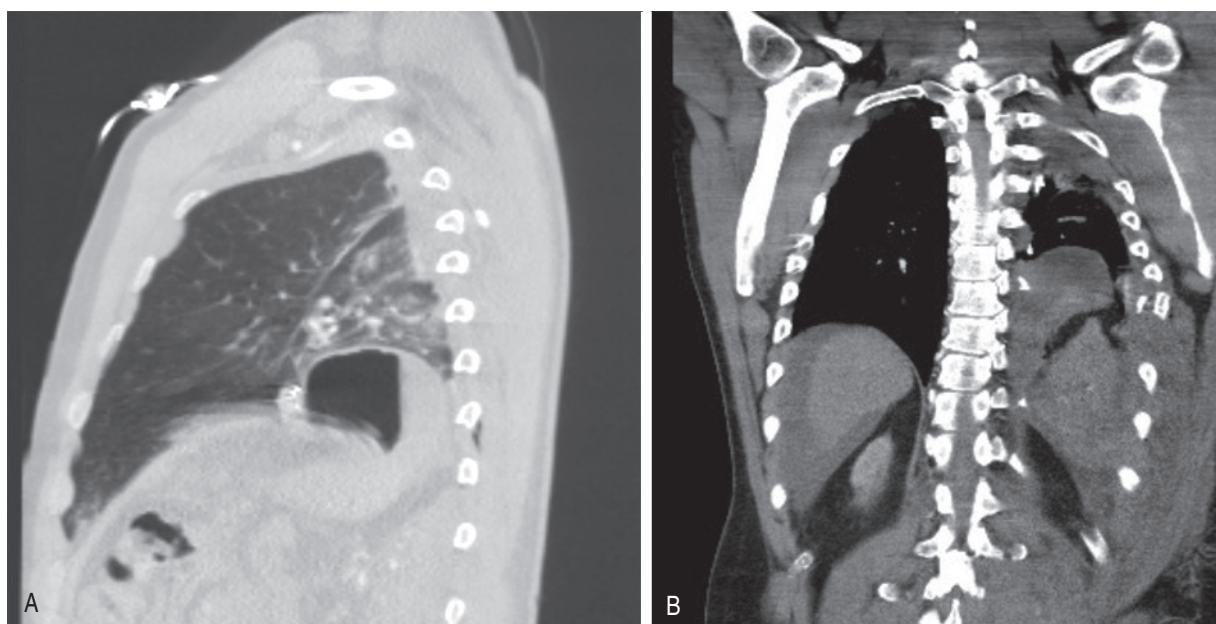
Traumatic diaphragmatic hernia on computed tomography. Axial lung windows demonstrate the stomach is above the diaphragm. The defect is best seen on the coronal soft tissue reformats.
